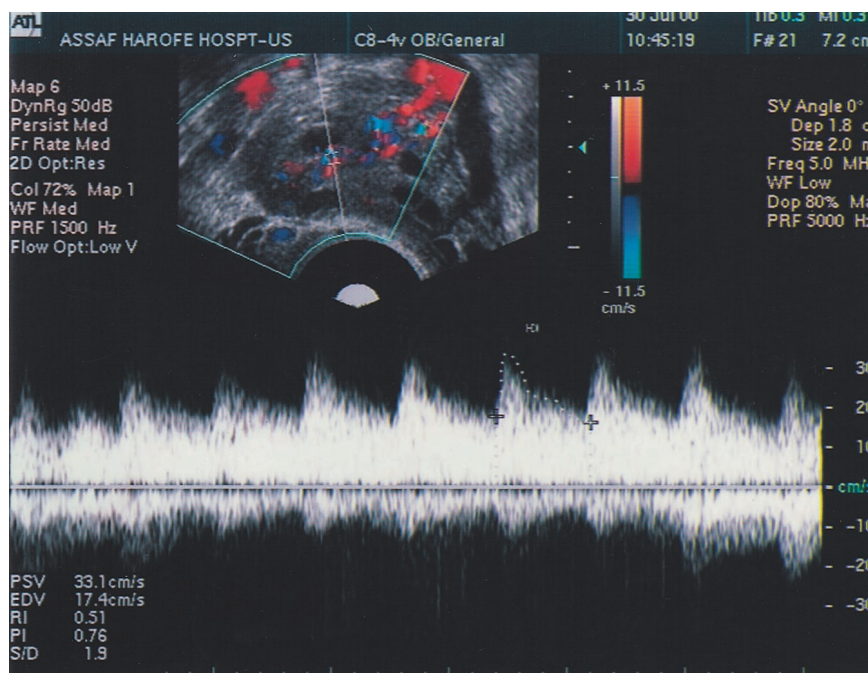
Normal adnexal blood flow, displayed by color Doppler transvaginal ultrasonography. Red indicates flow toward the transducer, and blue, away from it. The Doppler pattern can differentiate between arterial and venous flow by the pulsation pattern (continuous nonpulsative flow indicates a venous flow). Absence of flow, in addition to the clinical symptoms, raises the possibility of adnexal torsion.
